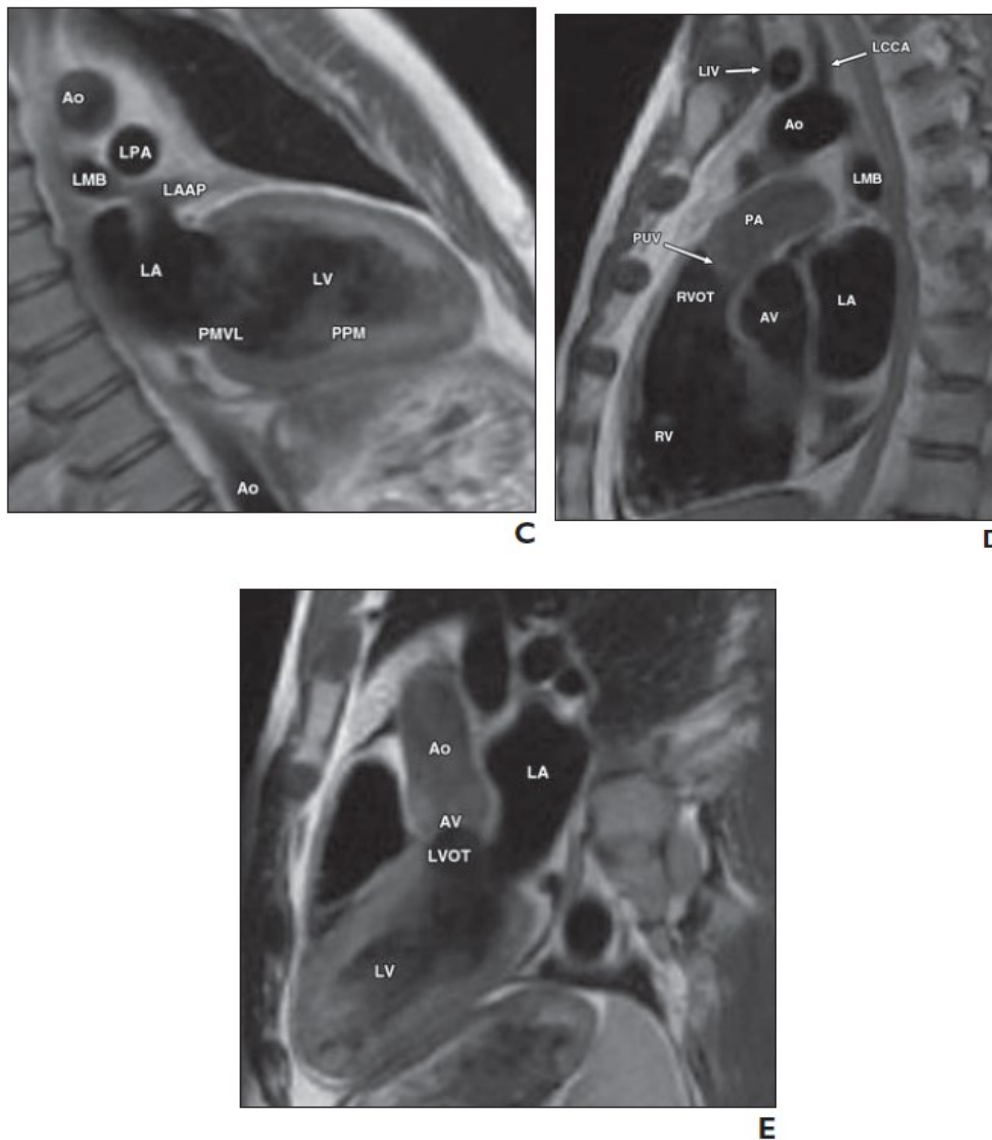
Normal cardiac MRI anatomy. Two-chamber (C), right ventricular outflow tract (D), and left ventricular outflow tract (E) views.
